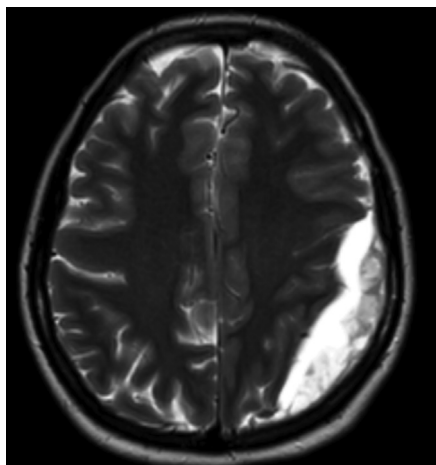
Imaging with a MRI scan of the patient
